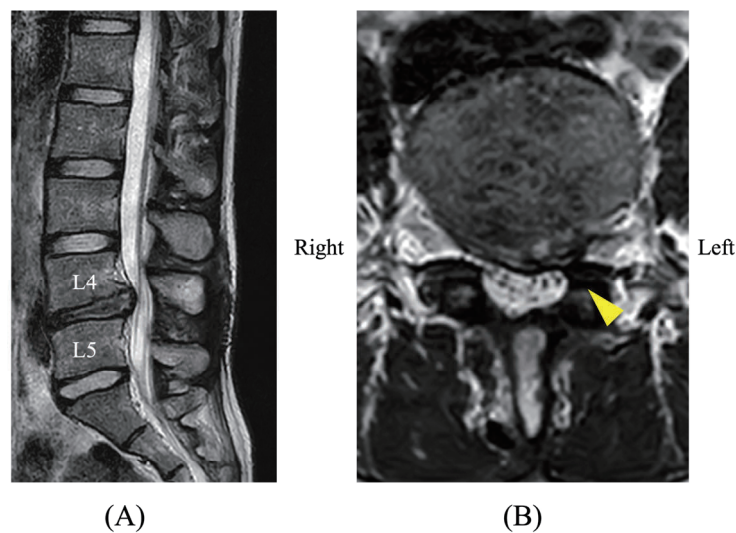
Postoperative MRI showing the site of decompression indicated by the yellow arrowhead.
